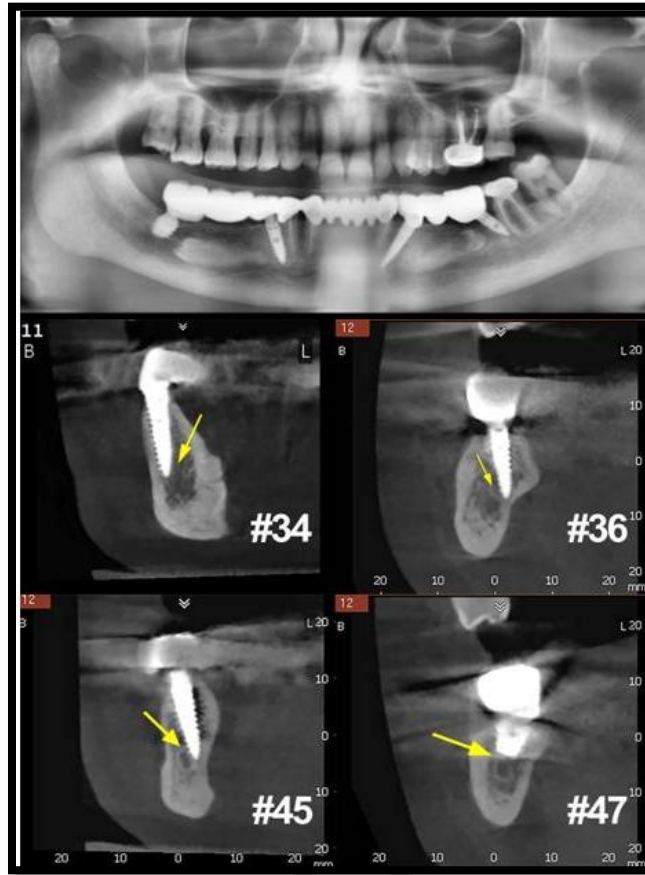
Radiographic view of 3 year follow up of prosthesis showing stable crestal bone and no signs of inflammation
